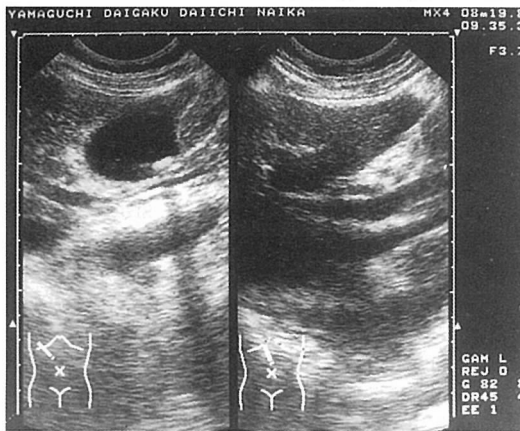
Ultrasonography on one day before admission. One gall stone was shown in the gall bladder.
